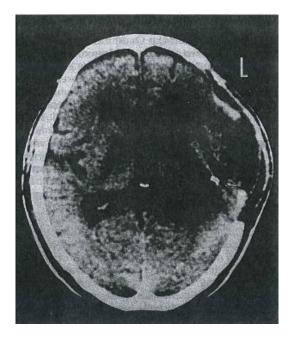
shows a CT scan taken after a decompressive craniectomy. It reveals swelling at the site where part of the skull was removed, and it also shows that the ventricles, which are fluid-filled spaces in the brain, are larger than usual, especially on the left side. An arrow points to a clip that was used to seal off a ruptured artery.
